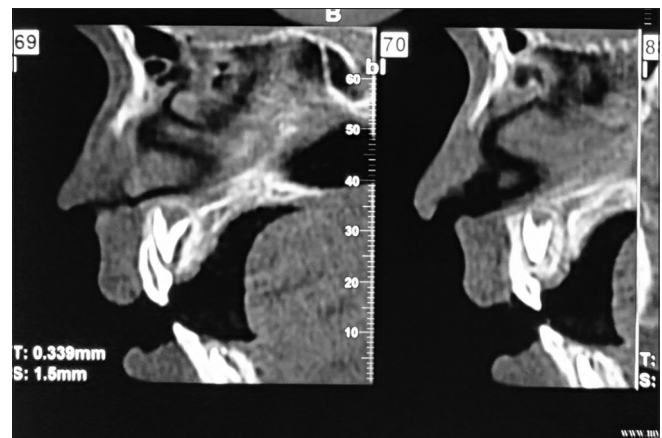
Axial and section cone-beam computed tomography confirmed the bony impaction of 61.
